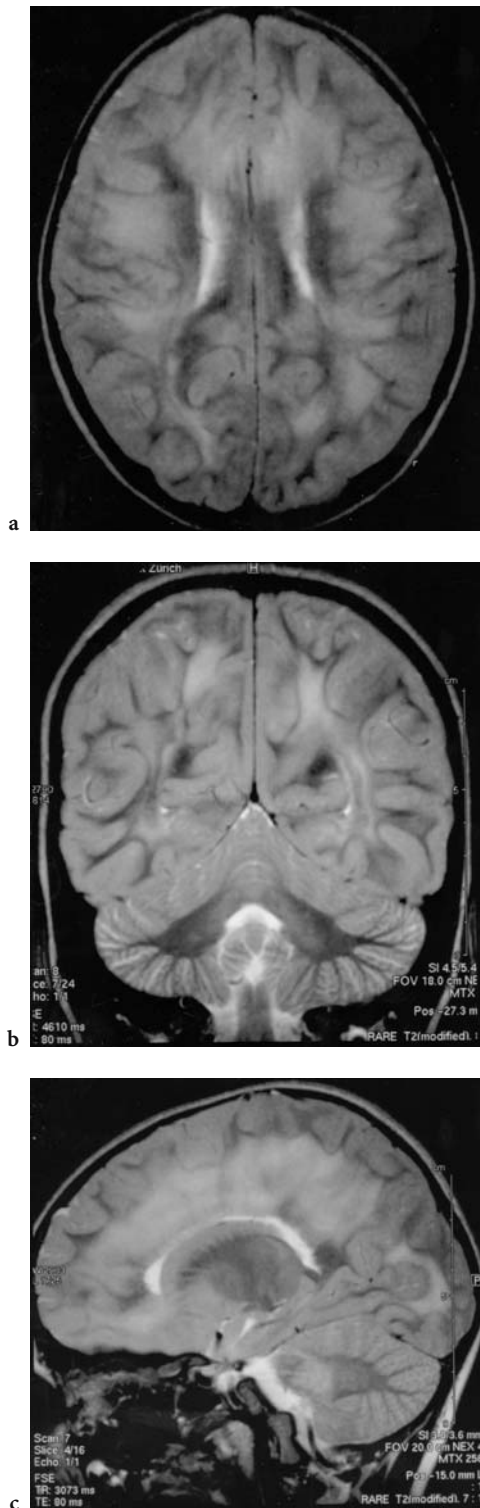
a Axial, b coronal, c parasagittal T2-/FSE MRI of a 6-year-old boy with drowsiness and reduced vision: extensive confluent T2 signal alteration of supratentorial and cerebellar white matter. Clinical diagnosis: acute disseminated encephalomyelitis (ADEM). Subsequent incomplete recovery with marked bilateral visual impairment
